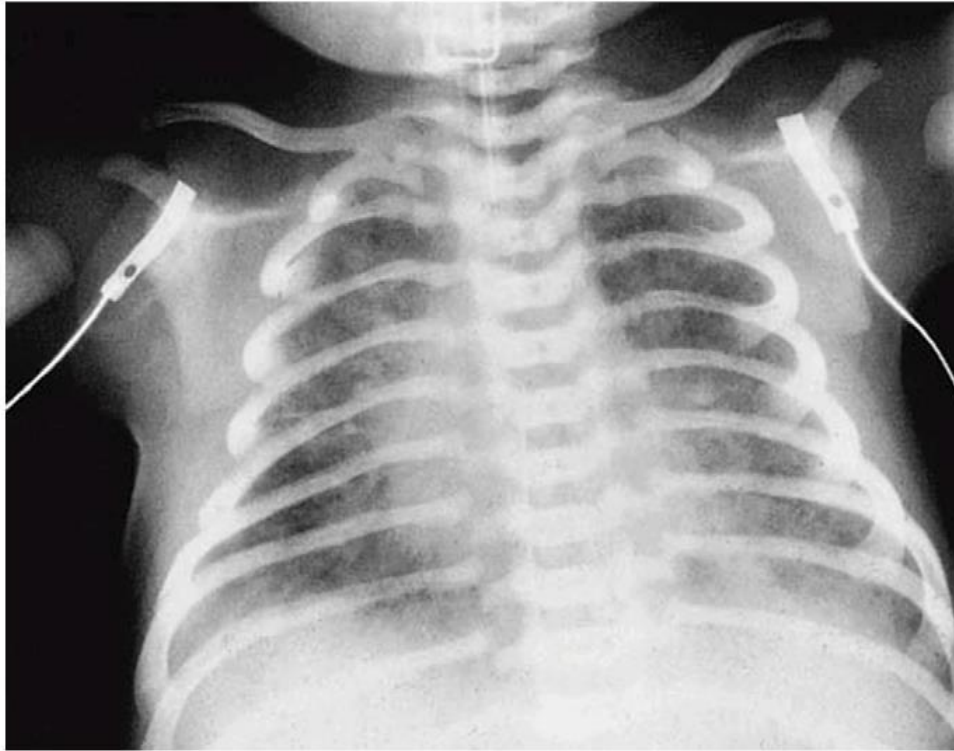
Chest X-ray in a baby with Meconium aspiration syndrome²³
